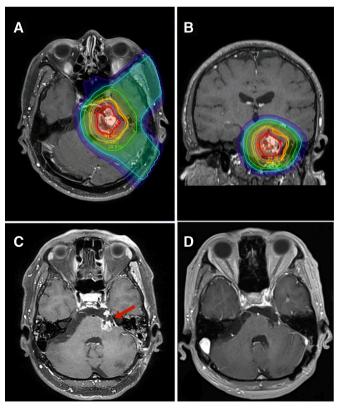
(A) Axial and (B) coronal colorwash isodose distribution for proton beam therapy. (C) MRI was taken in the treatment period showed a shrinkage of the tumour. (D) The tumour was disappeared at the follow-up MRI taken at 2 months after proton beam therapy.
